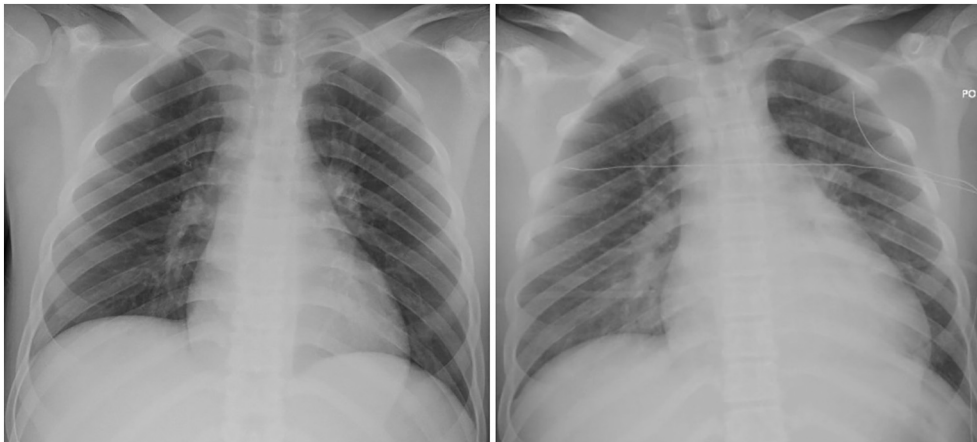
Chest x-ray changes.
